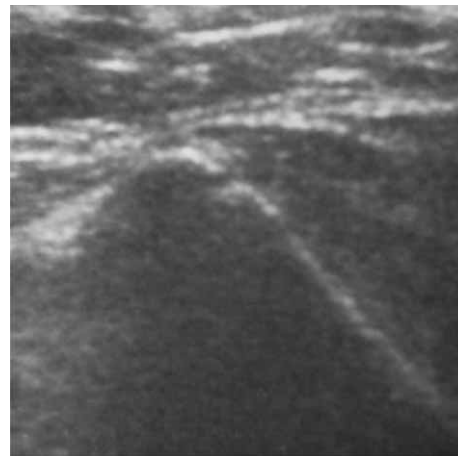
Risser 4b grade: in transverse sonogram of iliac bone, there is less than 2 mm of cartilage between iliac apophysis and iliac wing.
